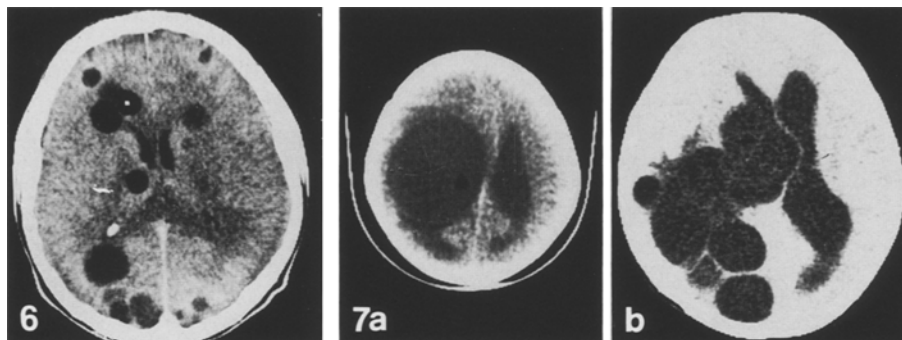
Enhanced CT scan of multiple hydatid cysts in different regions of the cerebral hemispheres. No perifocal oedema or enhancement are seen. Although some of the cysts are very close of each other as if they were multilocular, some are unilocular small lesions
